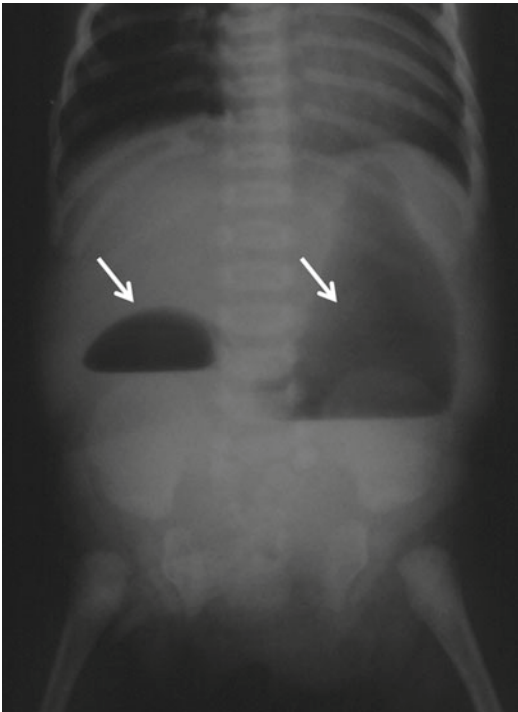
“Double bubble” sign, with air-fluid levels in distended stomach and duodenum (*arrows*), is a nonspecific sign of proximal bowel obstruction. Constricting Ladd’s band is indistinguishable from atresia and other causes of congenital duodenal obstruction on plain radiographs
